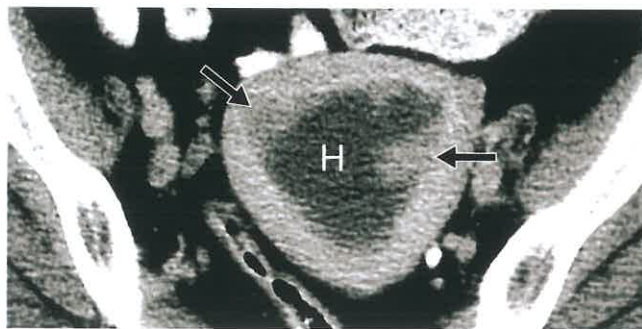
Endometrial Carcinoma—CT. Postcontrast CT image shows enhancing tumor nodules (arrows) invading the myometrium and extending into the uterine cavity being partially outlined by low attenuation hemorrhagic fluid (H). Tumor invasion is difficult to assess because the tumor is nearly isointense with enhanced myometrium.
